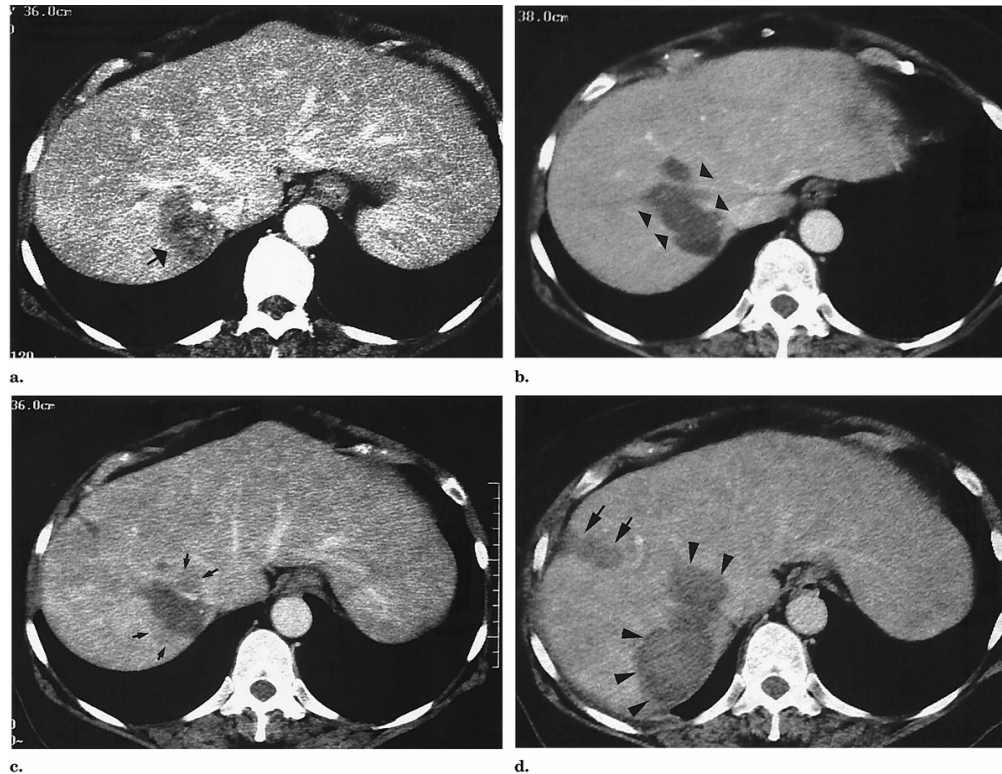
Incomplete treatment of tumor surrounded by blood vessels. *a)* A preoperative CT shows the location of the tumor near large hepatic veins. *b)* Initial treatment reveals defects in the ablation zone, manifesting as irregular borders. *c)* Nine months later, a CT study reveals local recurrence as shown by arrows. *d)* Ablations were performed to treat recurring tumors. Image reproduced from [32].
